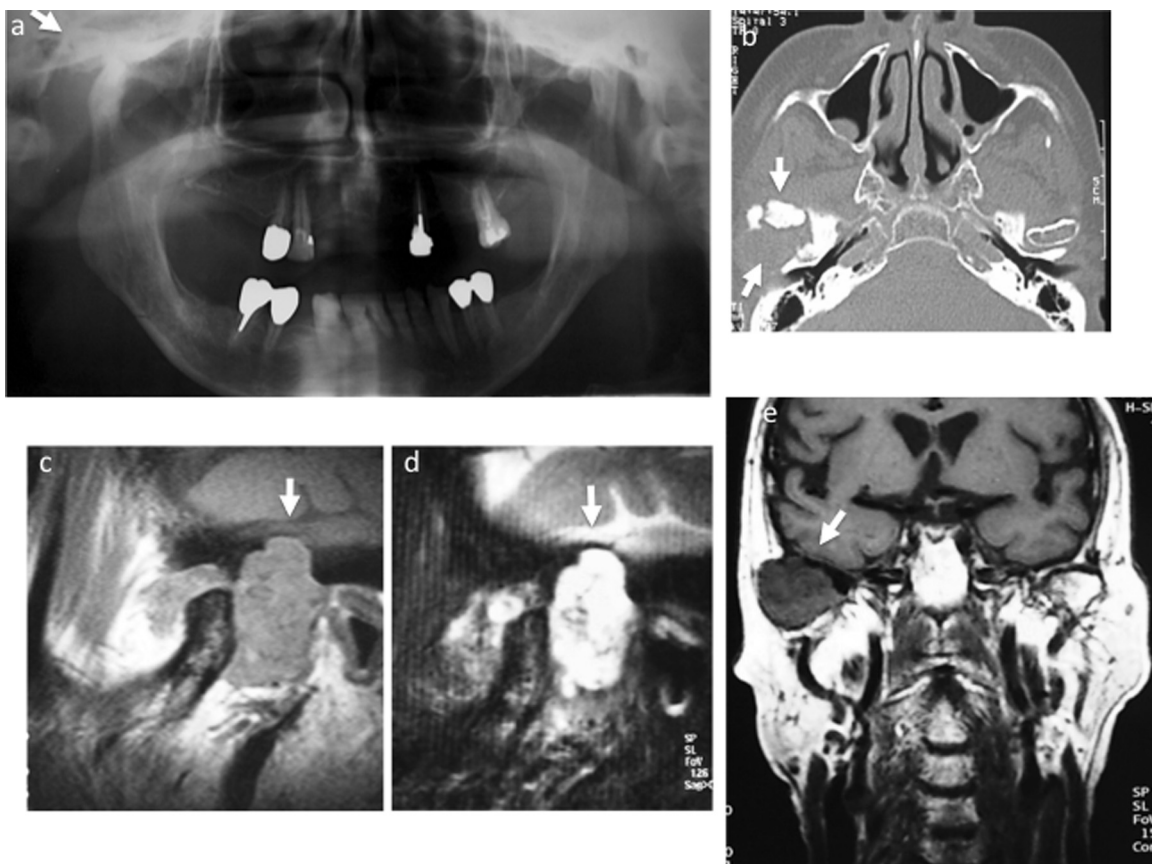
(a,b) The right-side mandibular condyle was displaced anteriorly by a mass lesion and severe bone resorption from the glenoid fossa to middle cranial fossa was observed on simple X-ray (a) and CT (b). (c–e) A large mass lesion near the cranial dura mater was confirmed on MRI, but invasion into the brain was not observed (c,e) PdWI, (d) T2WI).
